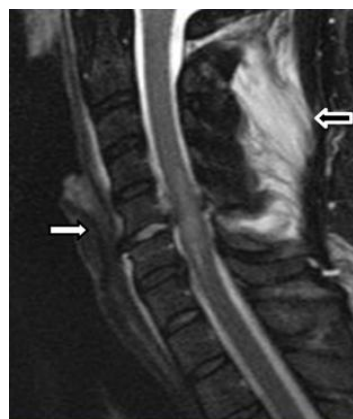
MRI of cervical distortion: (→) damage to the posterior ligaments; (⇨) damage to the anterior
